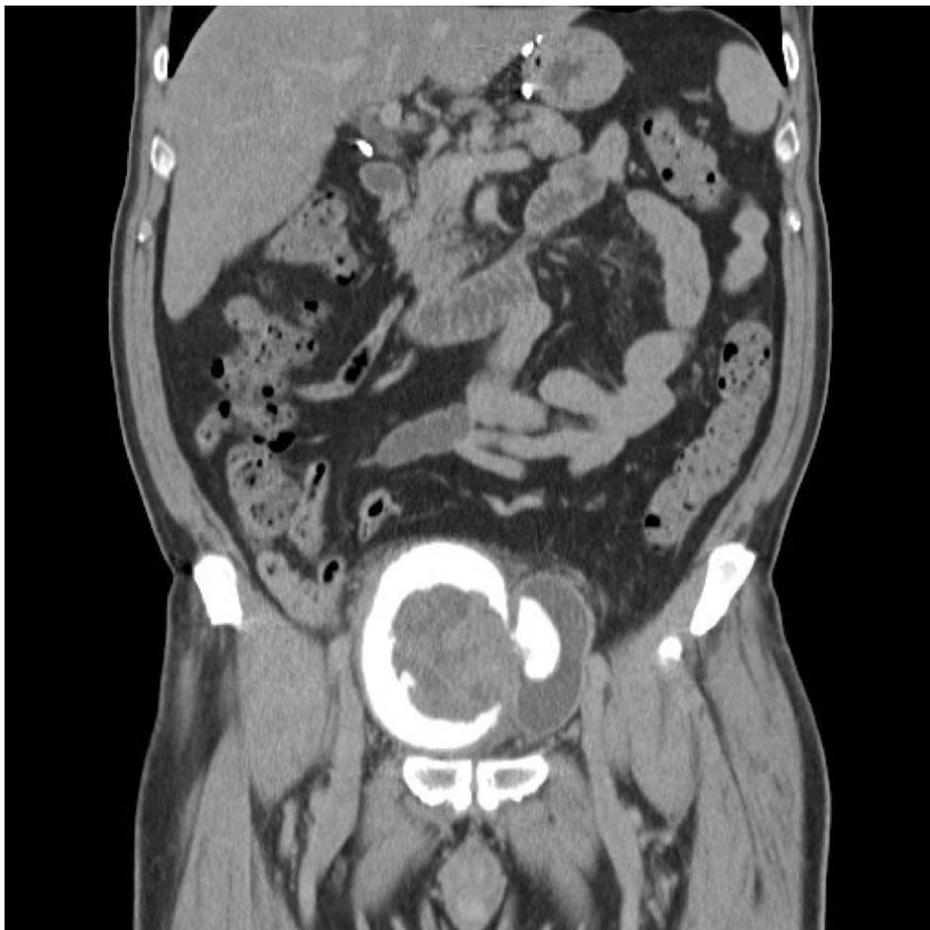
Pre-operative computed tomography (CT) scan showing bladder tumour of 5.2 x 5.1 cm with diverticulum measuring 8cm x 3cm in the left lateral wall. There was no lymphadenopathy or distant metastases.
